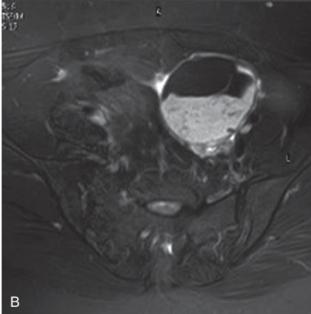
(A) Gross appearance of a cut-open dermoid cyst. Note the presence of hair-bearing skin. (B) MRI showing a dermoid cyst. (C) Tooth-like calcifications seen in the right hemipelvis suggestive of dermoids. (Source (A): Hacker NF, Gambone JC, Hobel CJ: Hacker and Moore's Essentials of Obstetrics and Gynecology, 5th ed. Philadelphia: Elsevier, 2010; Courtesy (B): Dr Parveen Gulati, New Delhi.)
